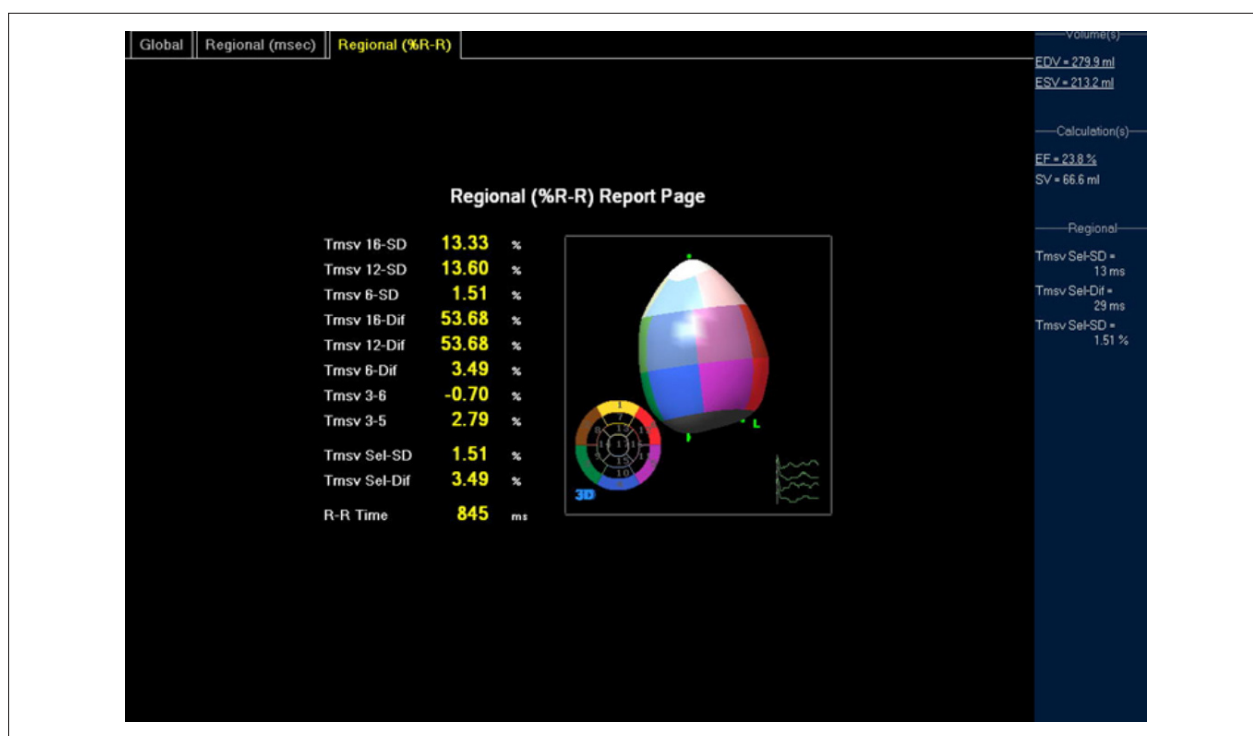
Real-time three-dimensional transthoracic image demonstrating the 16-ventricular segment dyssynchrony index (Tmsv 16 SD: 13.33%) in a patient with ventricular dysfunction and left ventricular dyssynchrony. EDV - left ventricular end-diastolic volume; EF - left ventricular ejection fraction.
